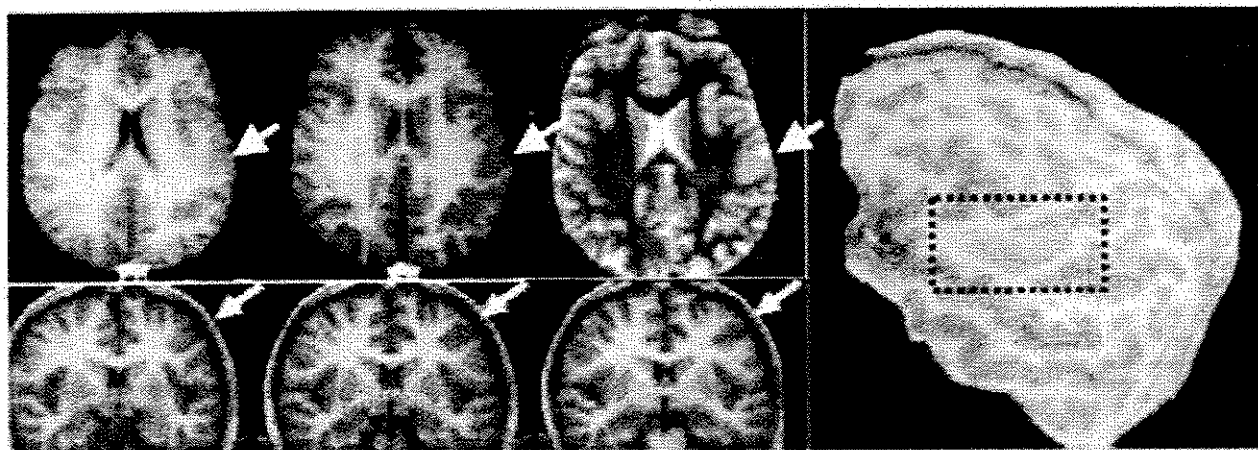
Patient 1. Clockwise from upper left-hand corner: axial T1-weighted images show that despite the change in the plane of section, the blurring between the gray and white matter (arrow) does not disappear, indicating that it does not represent volume averaging; axial T2-weighted image shows the hypersignal in the lesion (arrow); curvilinear reformation at 16 mm of depth from the cortical surface shows the dysplastic area in the left postcentral gyrus (box); and sequence of thin (2 mm) coronal T1-weighted images shows the dysplastic area (arrow) in 3 consecutive slices in plane.
